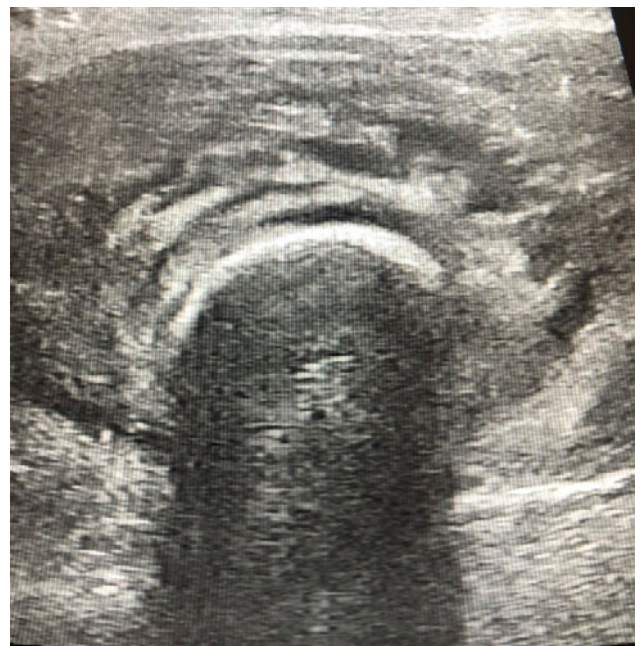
ultrasound of the femur, transverse projection, upper 1/3 of the femur, without pathological involvement of the cortex
